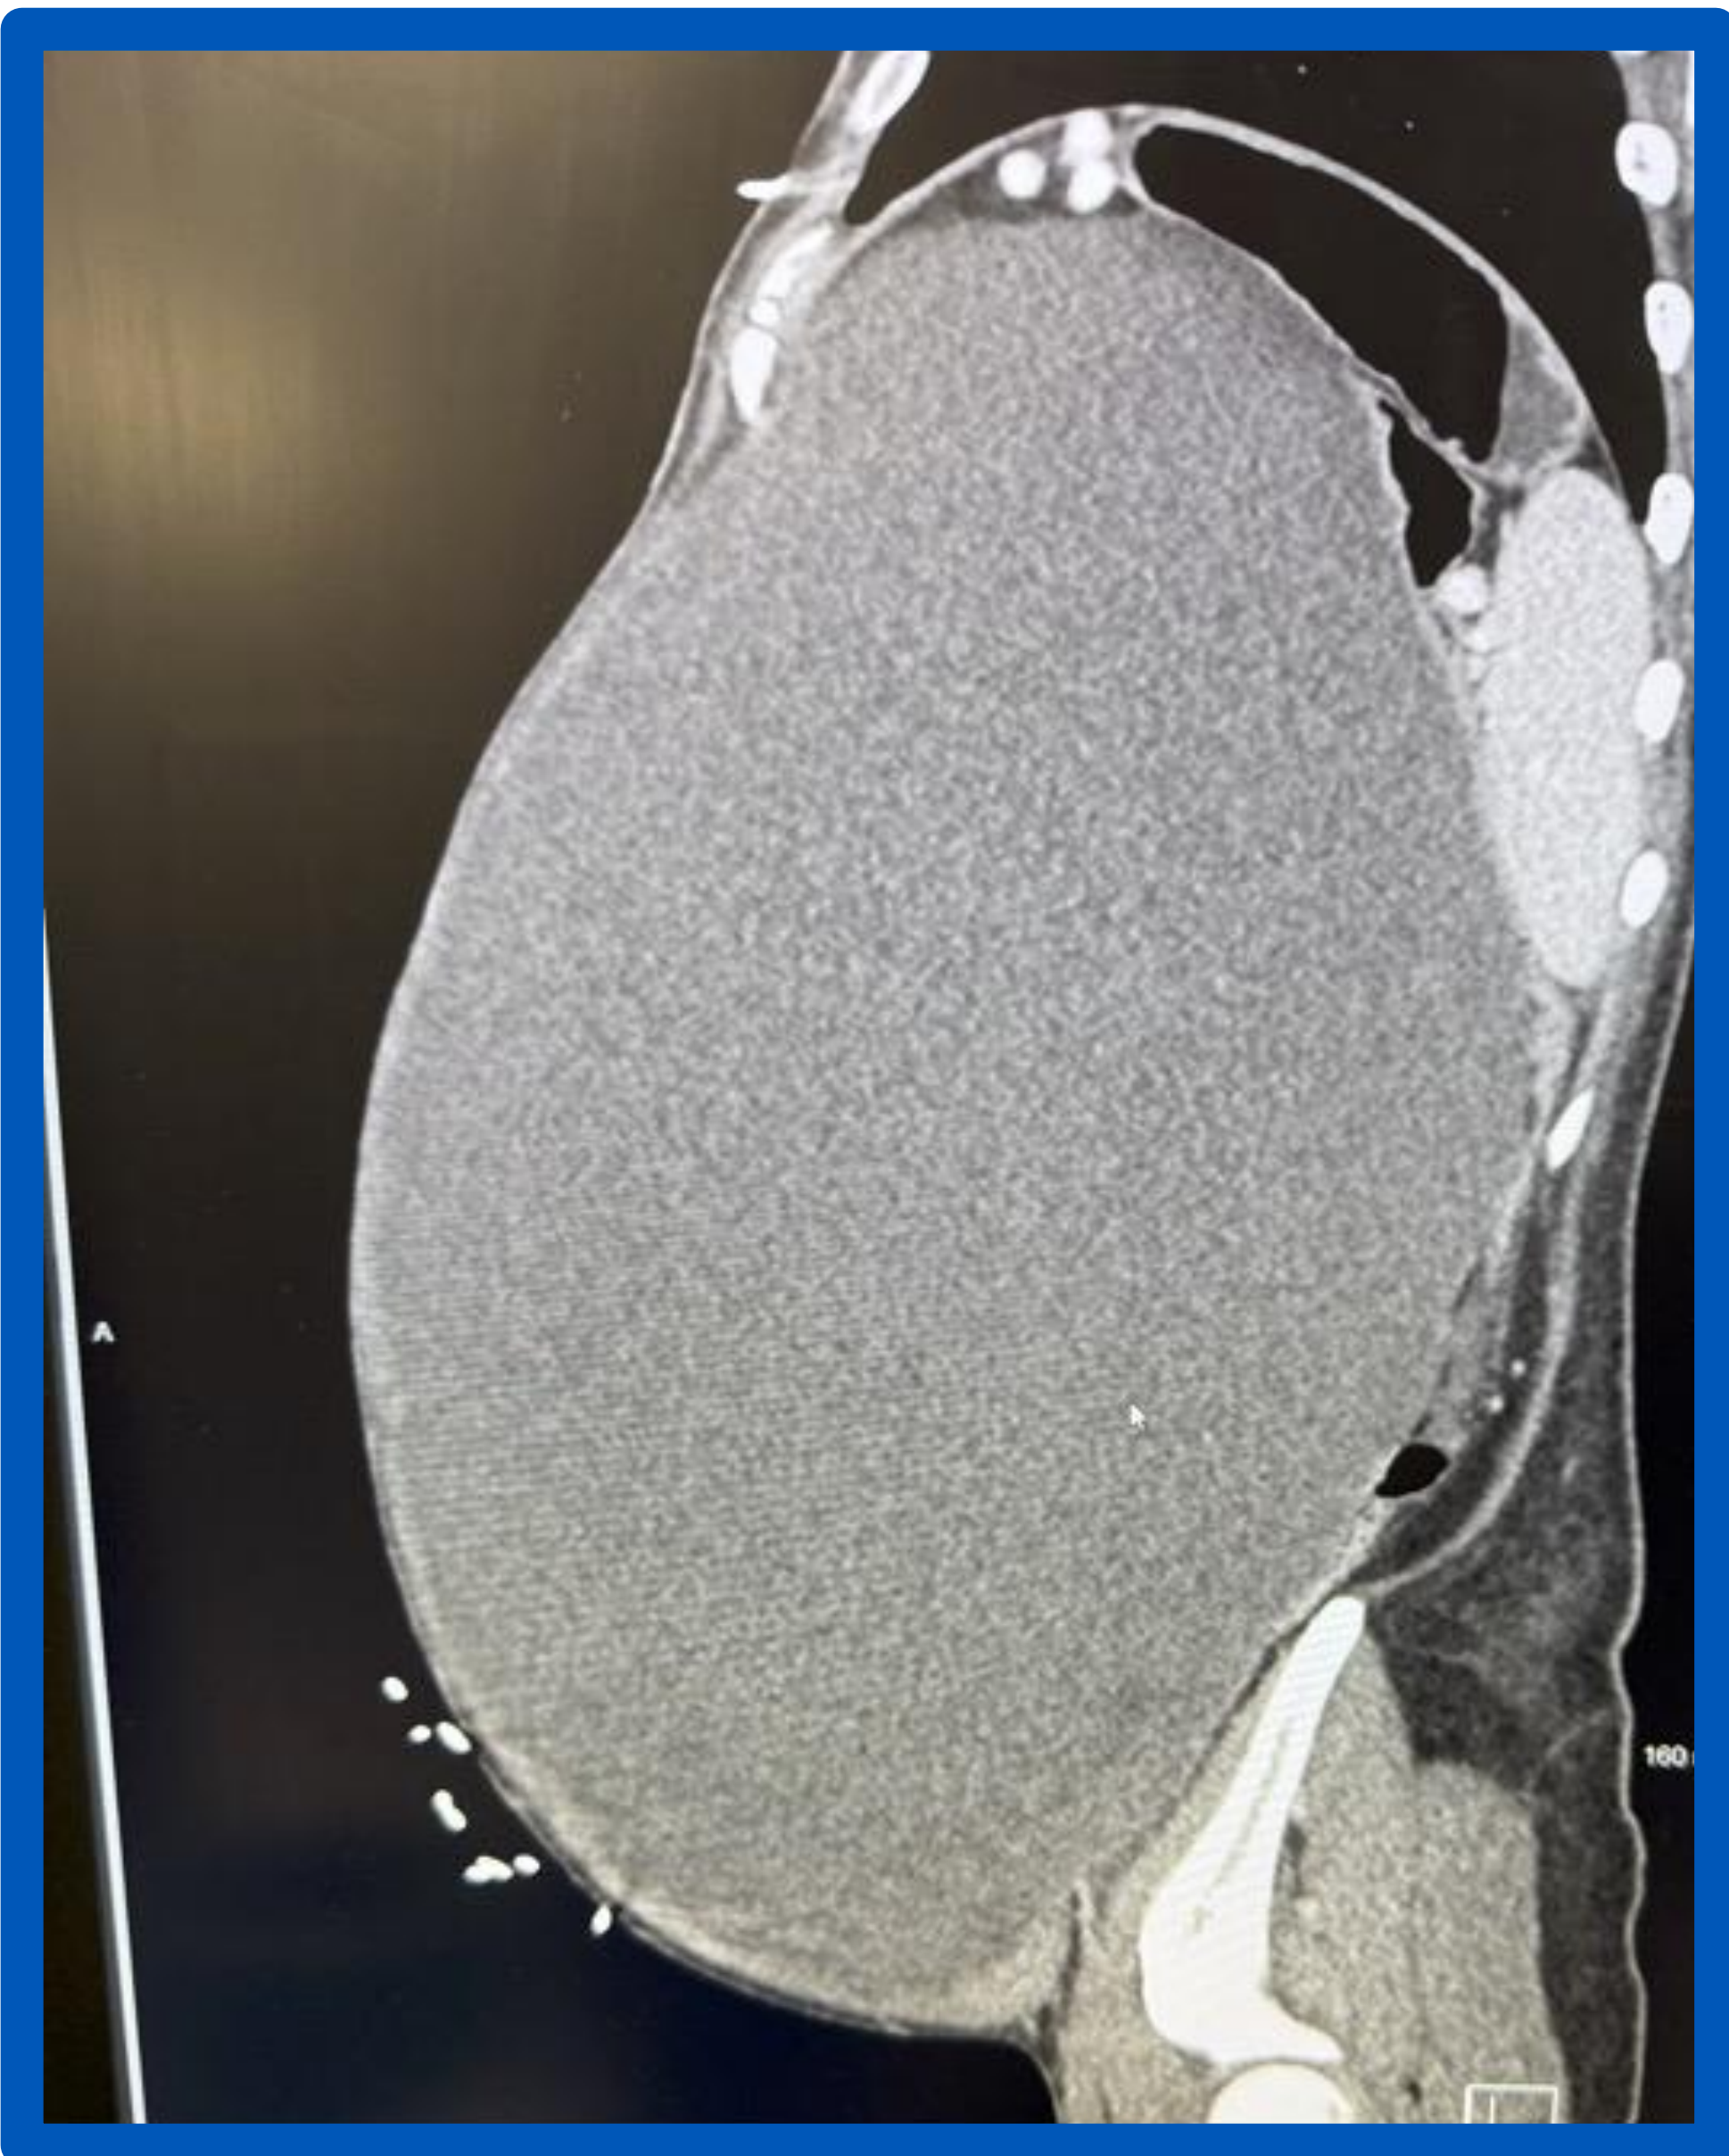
CT scan performed in the emergency department.
